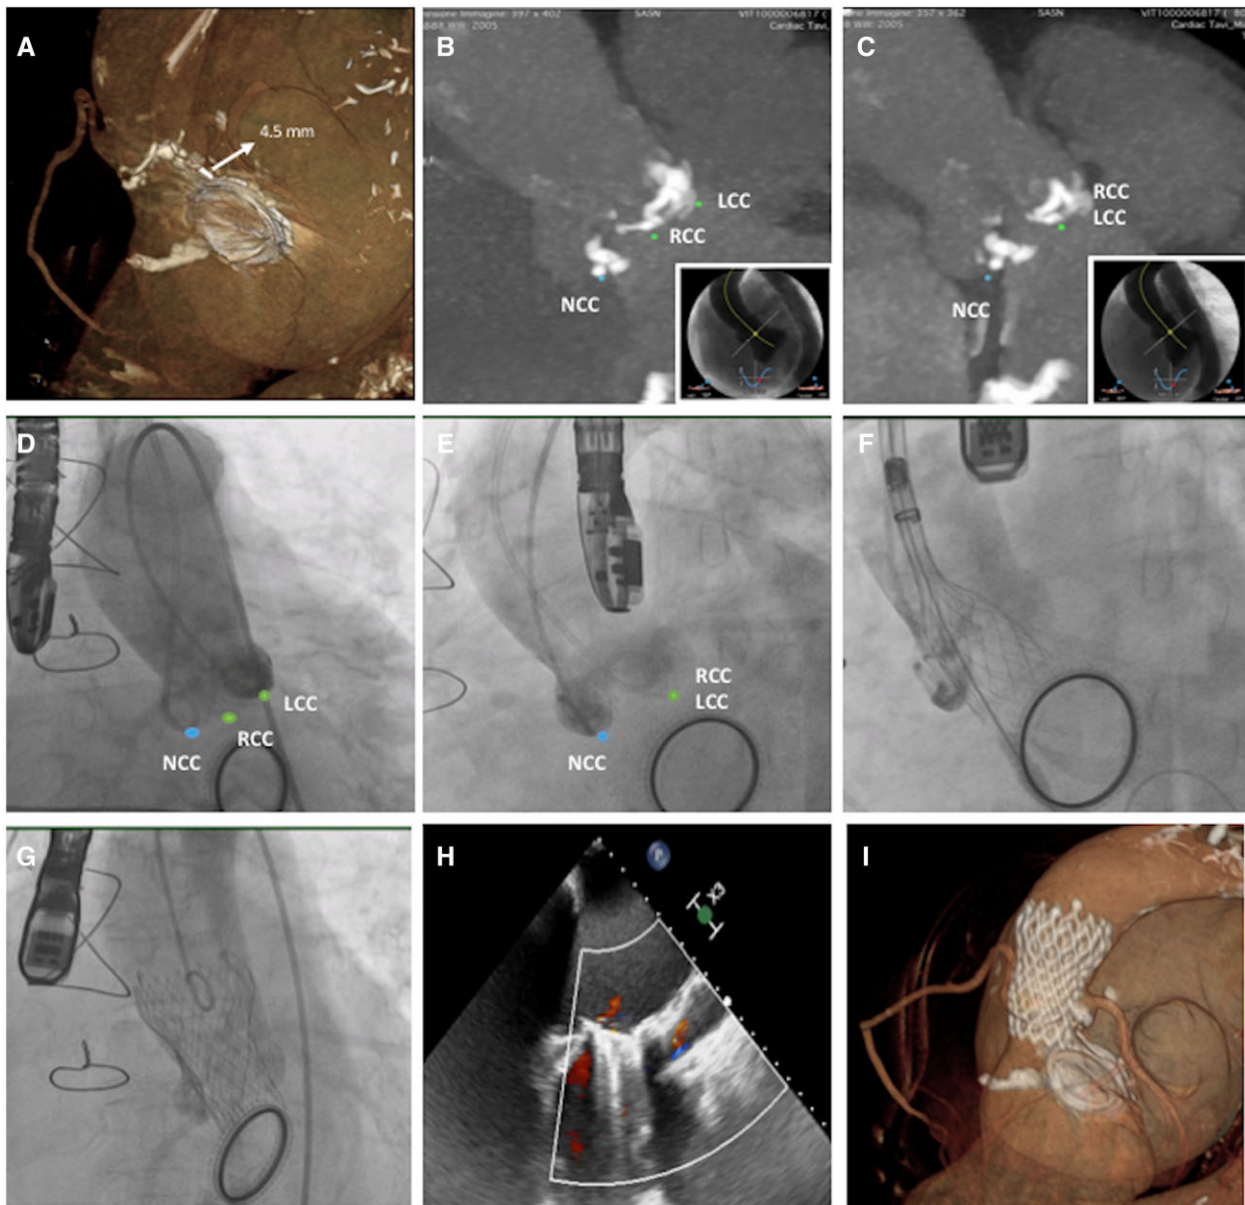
(A) Pre-operative computed tomography demonstrating the minimum distance between aortic annulus and mechanical mitral valve and identifying both three-cusp (B) and cusp-overlap views (C). Pre-implantation aortography confirming both three-cusp view (D) and cusp overlap view (E). (F) Successful implantation of 26 mm Evolut R valve with in cusp-overlap view and validation in three cusps view (G). (H) Post-implantation transoesophageal echocardiography demonstrating perfect bioprosthetic valve function. (I) Post-transcatheter aortic valve implantation computed tomography confirming high implantation and no interference with mechanical mitral valve.
